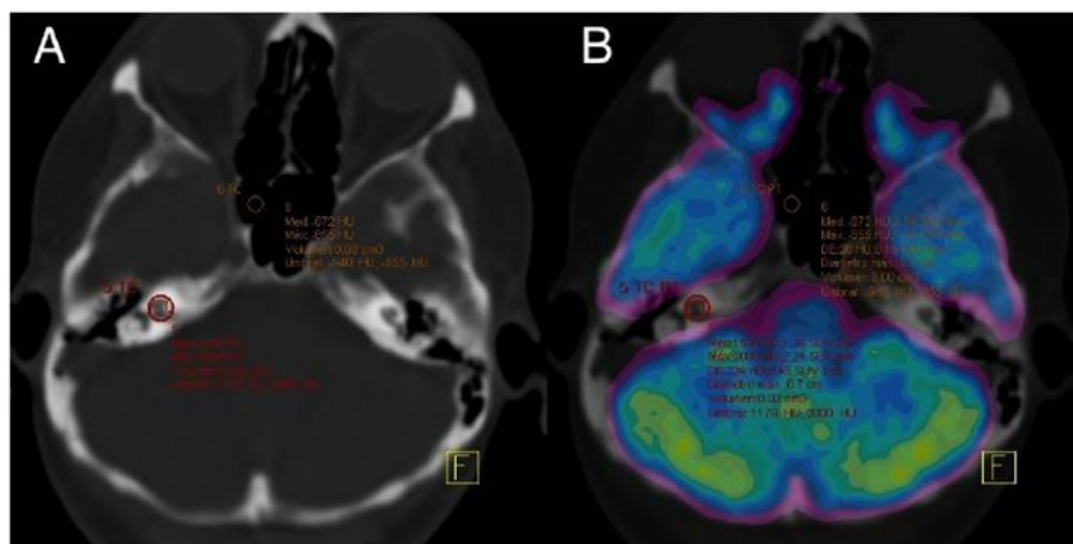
Transaxial view of (A) CT (B) fused PET/CT, (C) PET images showing the ROI 1 placed at the inner ear level in which more cochlear membranes can be depicted and ROI2 placed at the sphenoid sinus to assess background activity level. (D) Maximum intensity projection.
